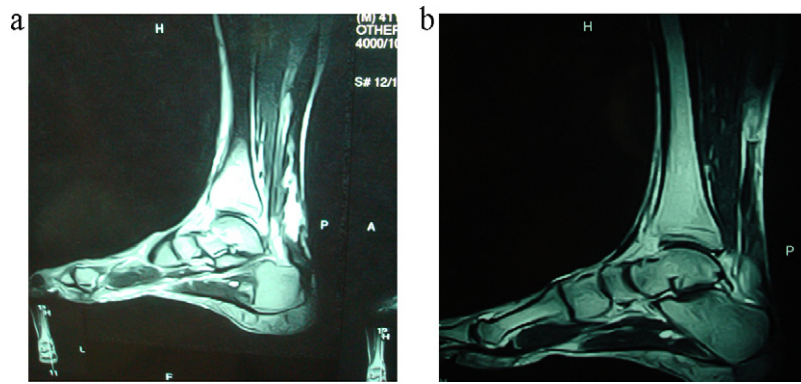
Preop MRI – T1 and T2-weighted images showing large gap between tendon ends.
